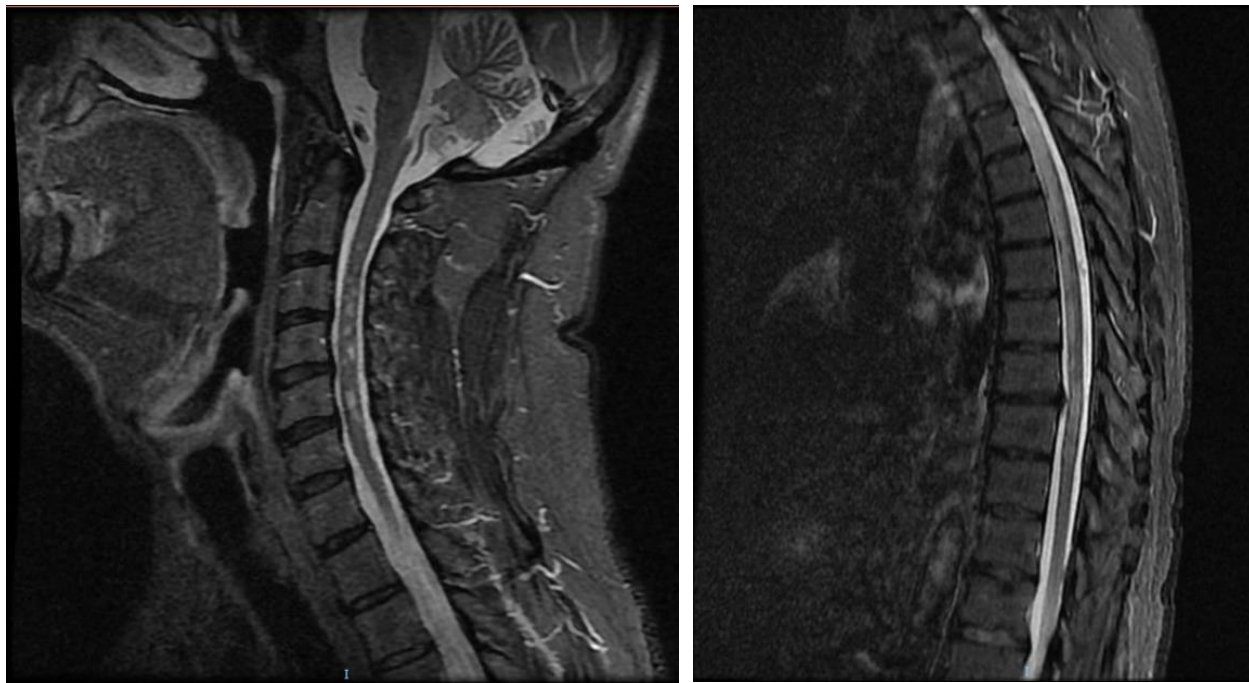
MRI of the cervical (left) and dorsal (right) spine, sagittal plane STIR sequence showing extensive segmental and continuous hyperintense lesions in the spinal cord.
